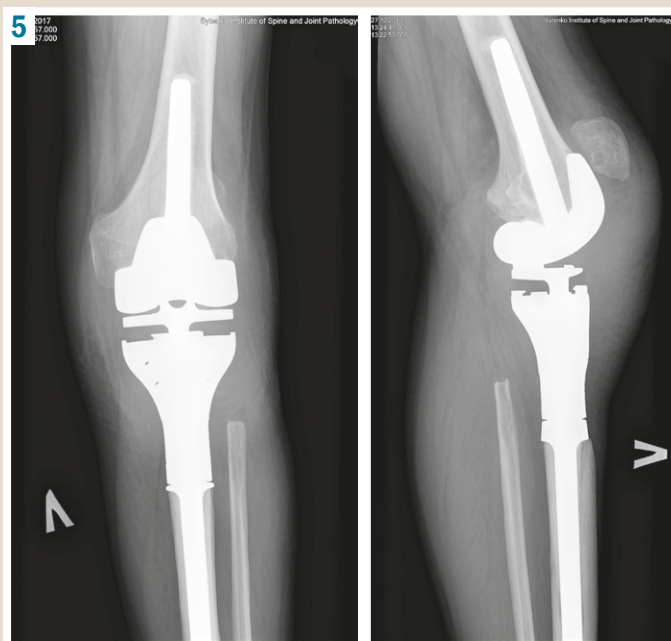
X-ray images with knee ligament detachment after primary endoprosthetic replacement using the GMRS system (Stryker, USA).
